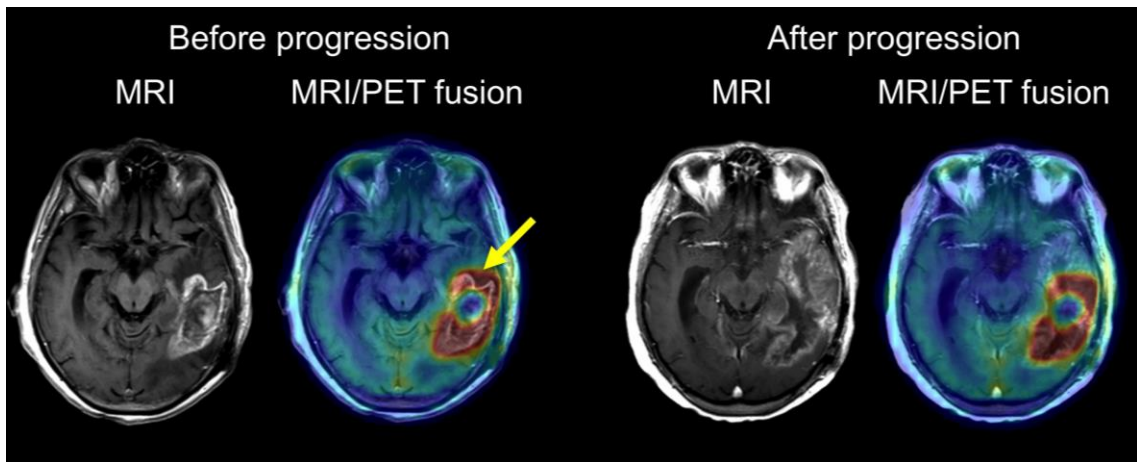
Glioblastoma progression with a large contrast-enhancing area and high AMT uptake in the left temporal region. The PET+ area extended anterior to the Gad+ lesion (arrow), with an SUV_{max} of 5.4. T1-Gad MRI 5 months later showed extension of the contrast enhancement into the anterior temporal lobe encompassing and extending beyond the baseline PET+ region.
